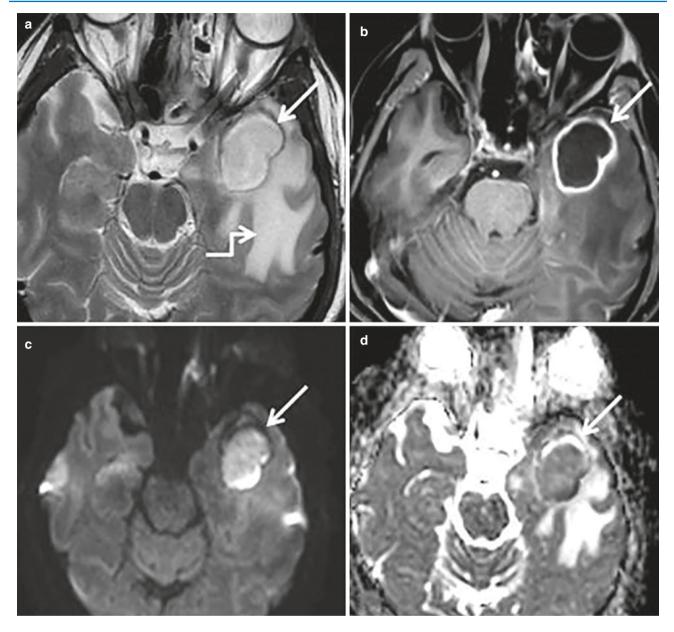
(a) Axial T2-weighted image shows well-defined hyperintense lesion (arrow) with hypointense wall and perilesional edema (stepped arrow) in left temporal lobe, (b) axial T1W postcontrast image
